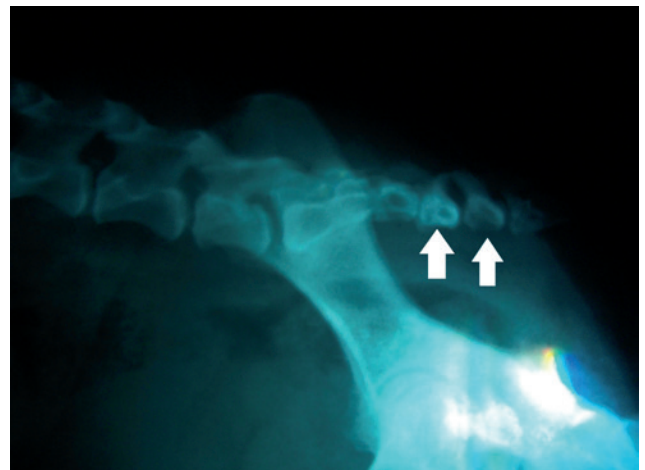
X-ray from a French bulldog of the German Club of French bulldogs with a screw tail due to a Hemivertebrae (white arrow)
